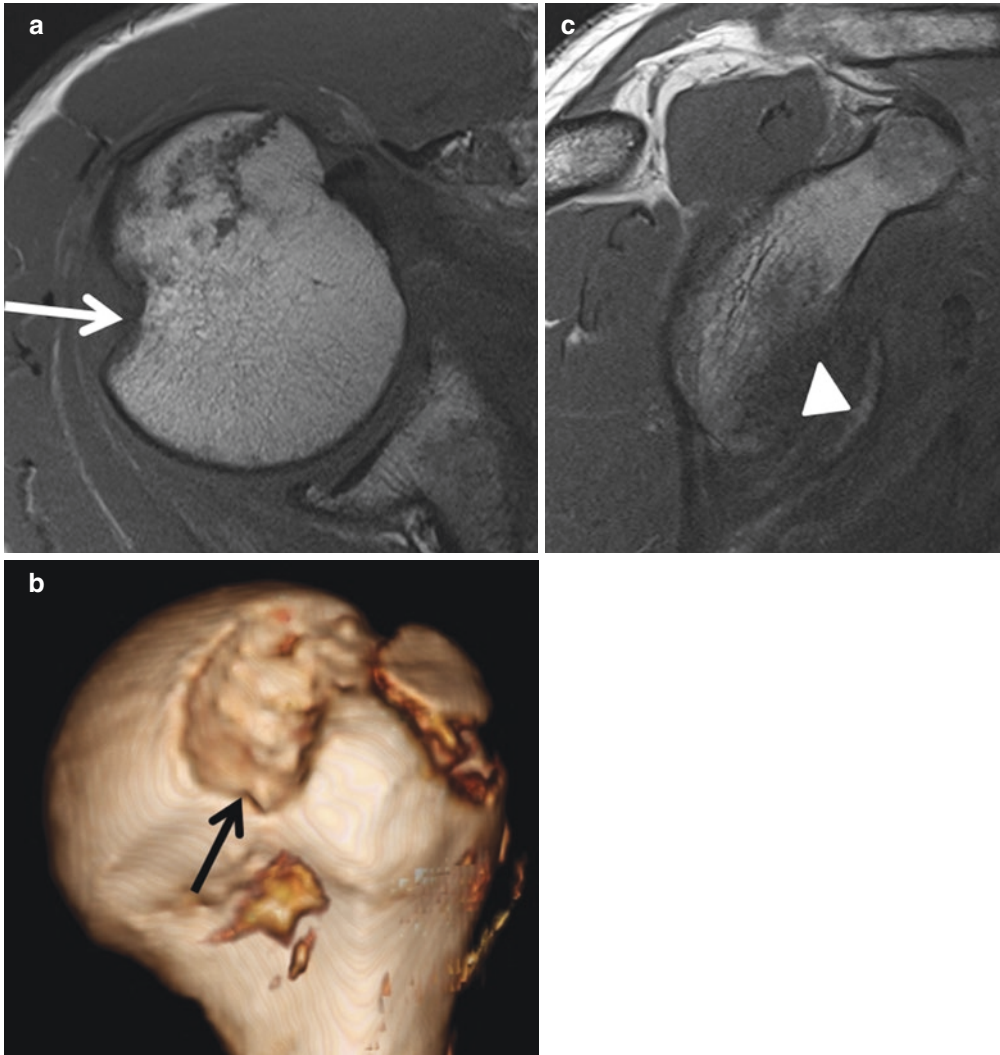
3D imaging. (a) Axial T1-weighted and (b) 3D images demonstrating a large Hill-Sachs deformity (arrows) in this patient with recurrent anterior shoulder
